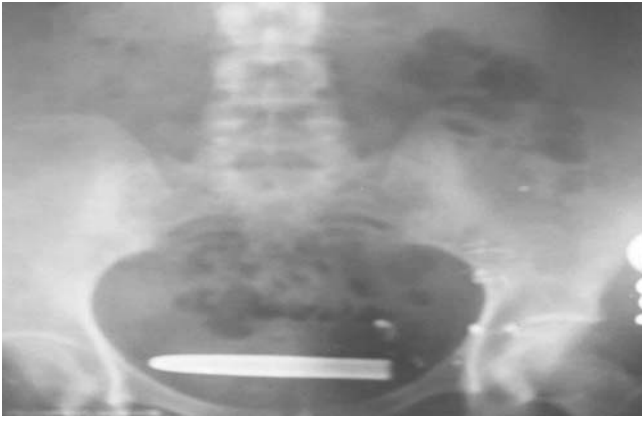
Direct urinary system X-ray
